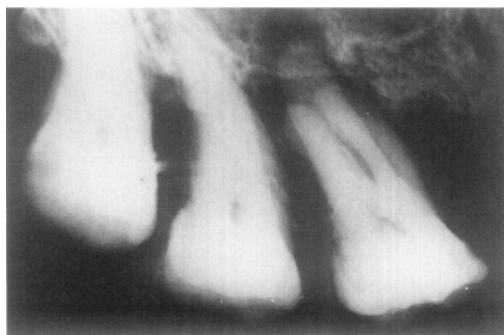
Clinical data: Maxillary right first molar of 45-year-old woman. No pain. Caries free. Calculus, periodontal disease, and bone loss involving 3/3 of the roots. Periapical lesions involving all of roots.
